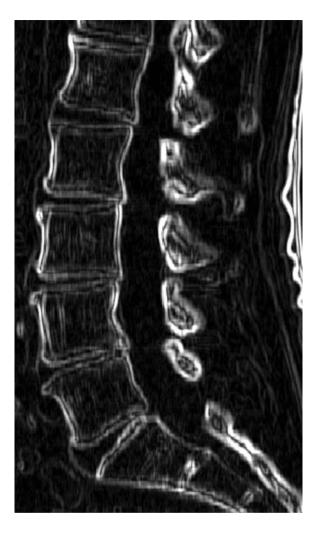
Range filter 3×3 window on the CT image [1]
